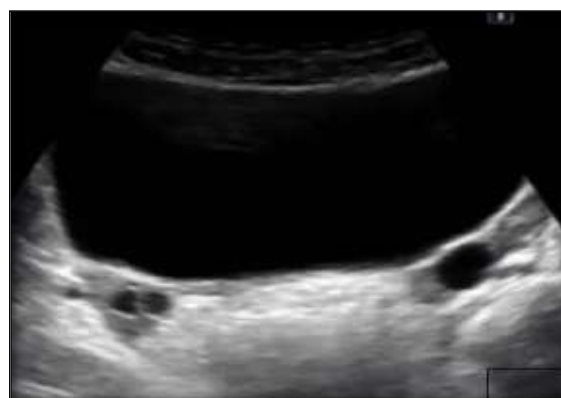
showing ultrasound images of normal bilateral ovaries with follicles
